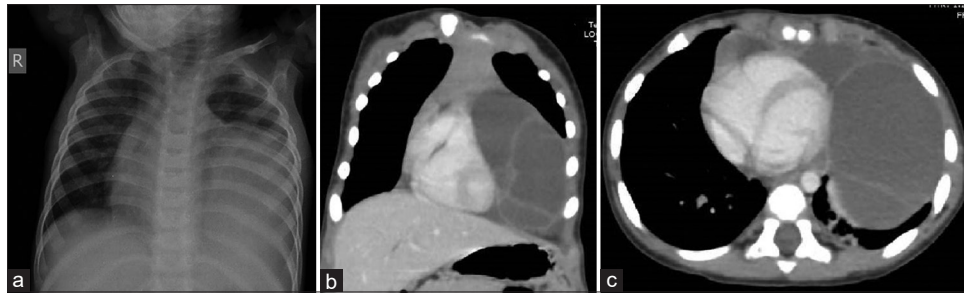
(a) Preoperative chest X-ray showing mass in the left hemithorax, (b) computed tomography thorax showing mass in the left hemithorax compressing the left ventricle, (c) computed tomography thorax showing two septations inside the mass
